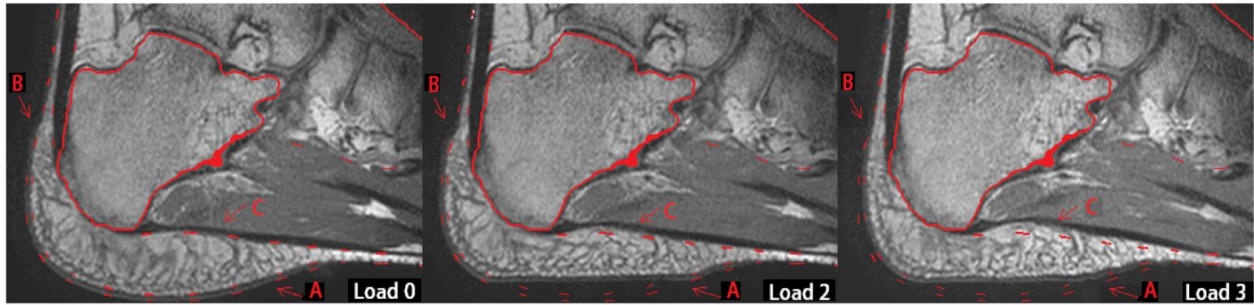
Sagittal MRI sequence of loading configurations in order to compare the effects of normal and shearing loadings. The red contours represent the segmentation of Load 0. Arrows A, B and C are placed in locations where the most clear impacts of the applied loads are visible. Load 0: no load ; Load 2:  $F_n$  as a normal load ; Load 3:  $F_n + F_s$  as a normal and shearing load.
